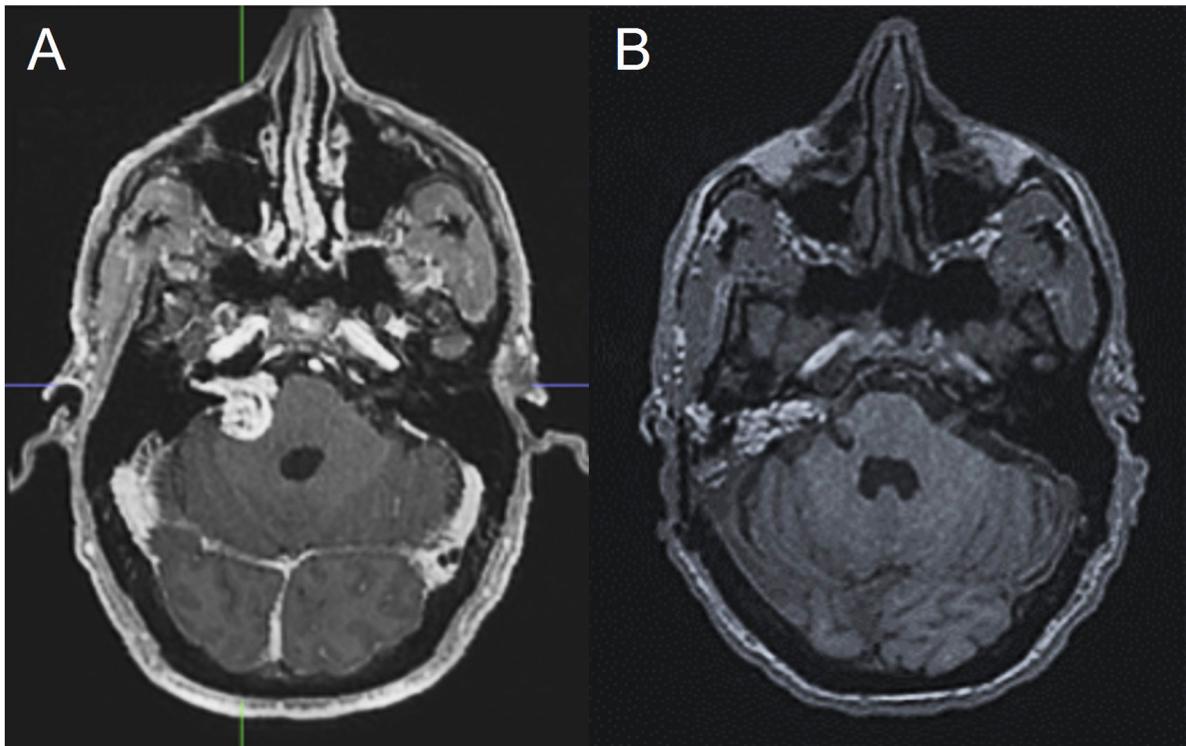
(A) Pre-operative and (B) post-operative MRI scans from Professor Eric (courtesy of Eric Sternlicht).
